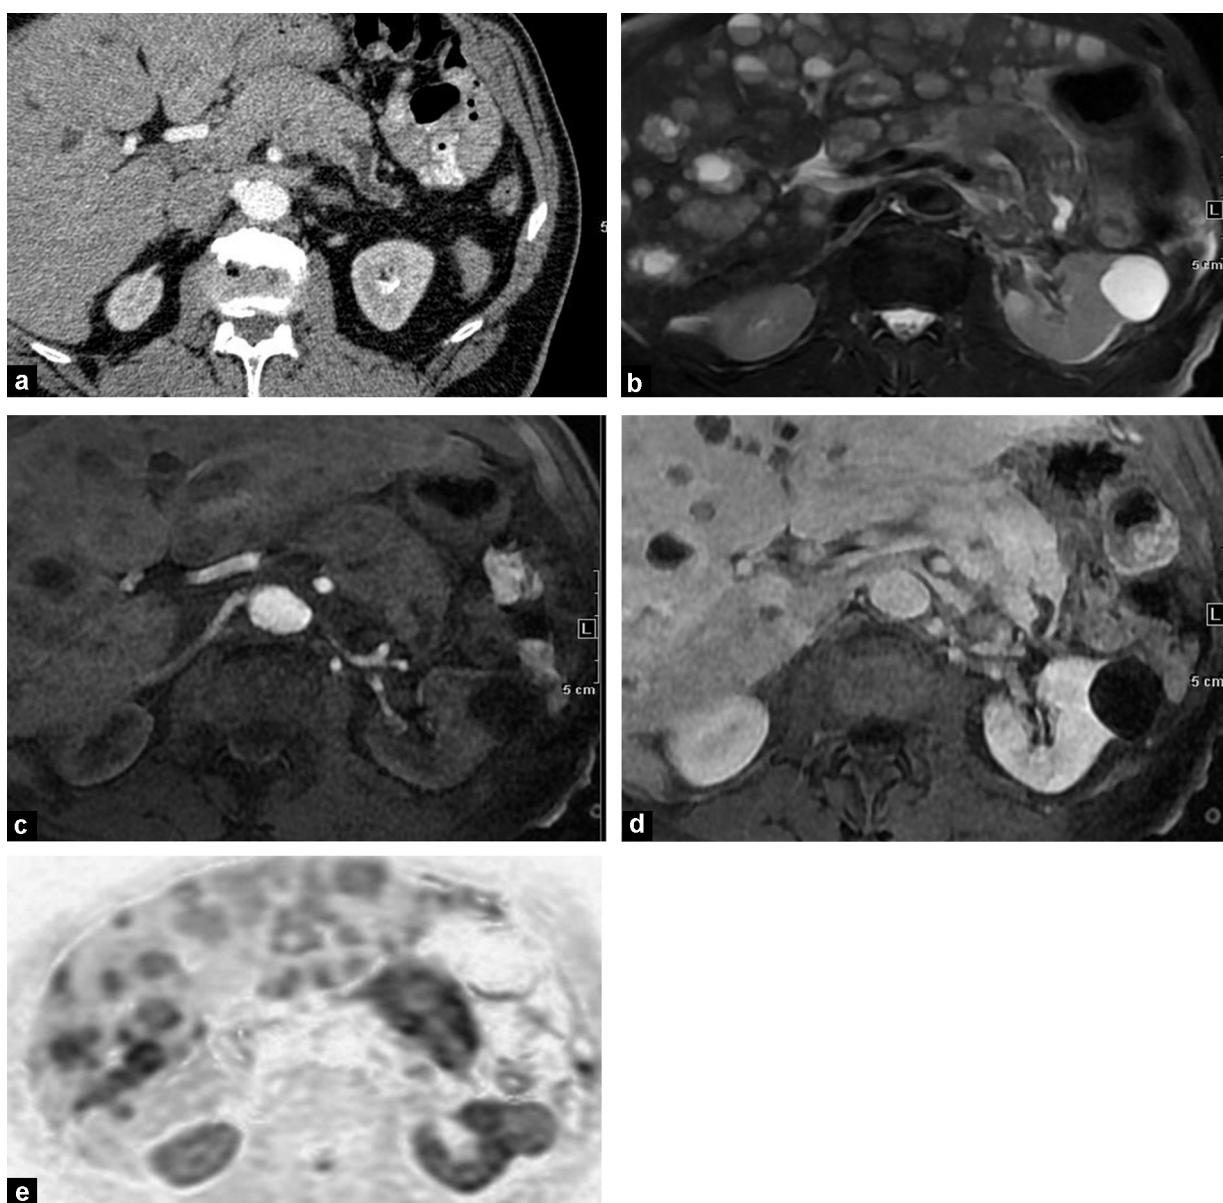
Malignant non-functioning pancreatic endocrine tumor. CT image (a) show a dilatation of the main pancreatic duct associated with an enlargement of the pancreatic gland, which remains isodense. T2-weighted image (b) shows a heterogenous hyperintensity associated with multiple liver metastases better depicted than on CT. The tumor is isointense on T1-weighted MR images at the arterial (c) and portal phase (d). The pancreatic tumor and liver metastases are also well depicted on DWI (e).
